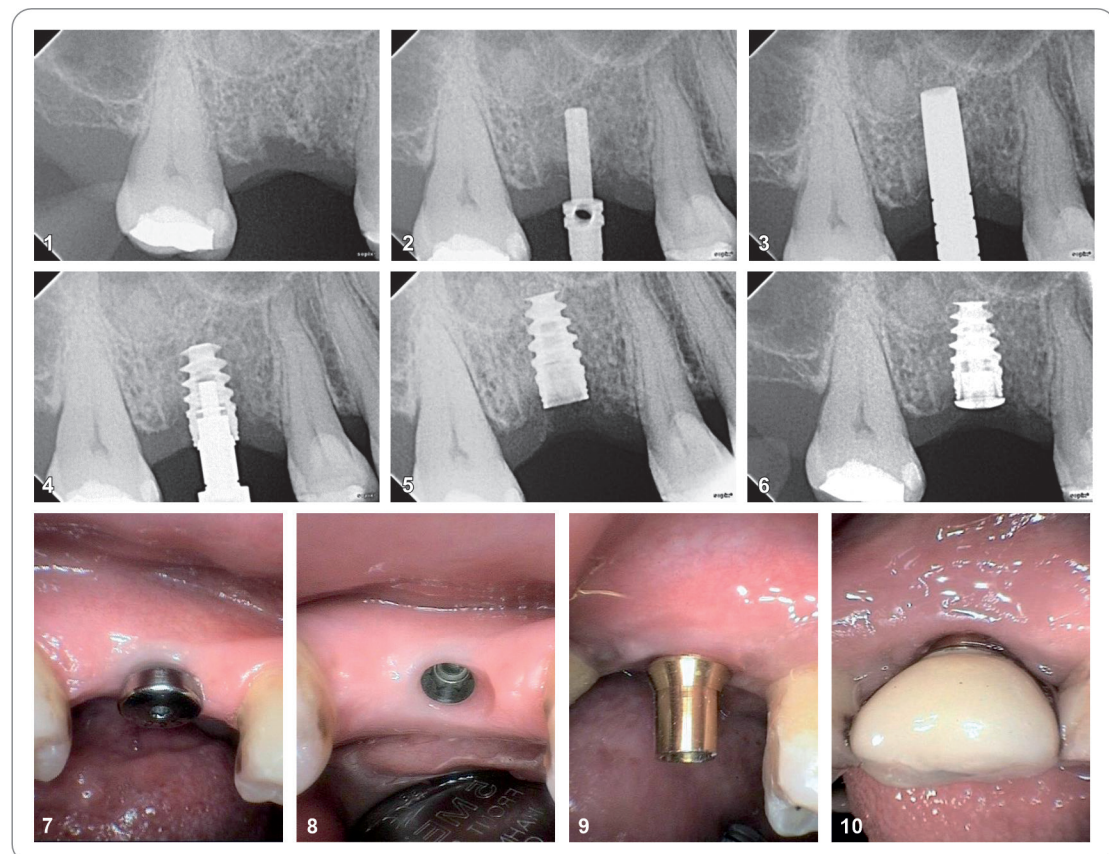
Clinical steps in placing an implant and indirect sinus lift in maxillary posterior area. Diag. 1: Pre-operative radiograph. Diag. 2: After initiating the osteotomy (1.8–2 mm drill) and reaching a depth of approximately 5 mm, direction indicating post is inserted into the osteotomy to know the direction of the osteotomy. Osteotomy is prepared to the desired length and diameter using drills of larger diameter in sequence (*base of the maxillary sinus floor in this case*). Diag. 3: Floor of the maxillary sinus at the end of the osteotomy is then fractured and lifted up 2–3 mm by using osteotomes (*indirect sinus lift instruments*). Diag. 4: Implant is then mounted on an implant driver and put into the osteotomy. It is turned clockwise to insert it into the osteotomy with an implant mount (*using physiodispenser and torque wrench*). Diag. 5: Implant is inserted into the osteotomy till the crest of the alveolar bone or just 0.5 mm apical to it. Diag. 6: Cover screw is fixed over the implant to prevent food, plaque and soft tissue growing into it. Diag. 7: Cover screw is replaced with a healing screw. Diag. 8: After allowing gingival healing for about 15 days, gingival collar forms around the healing screw (*abutment*). Diag. 9: Selected abutment is fixed on the implant. Diag. 10: Crown is fabricated and placed on the implant.
